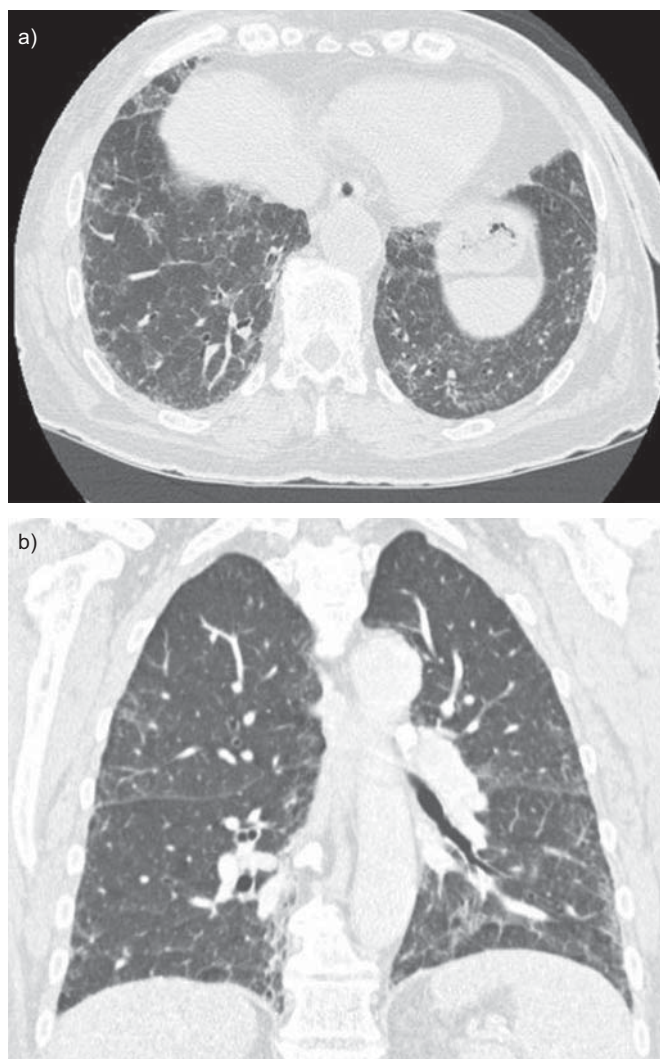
Chest computed tomography (CT) scan of a patient with pulmonary alveolar proteinosis secondary to myelodysplastic syndrome. The CT scan shows ground-glass opacities and reticulations mainly in the lower zone with patchy, slightly peripheral distribution. a) A horizontal section and b) coronal section.
